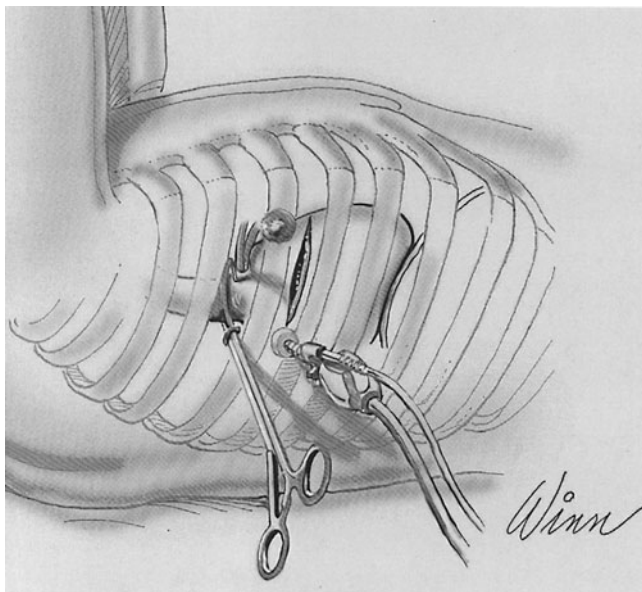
Right minithoracotomy and video access. The right minithoracotomy allows aortic access for the transthoracic clamp shown here as well as the video camera. With this arrangement minimal rib spreading is needed to perform mitral surgery.
